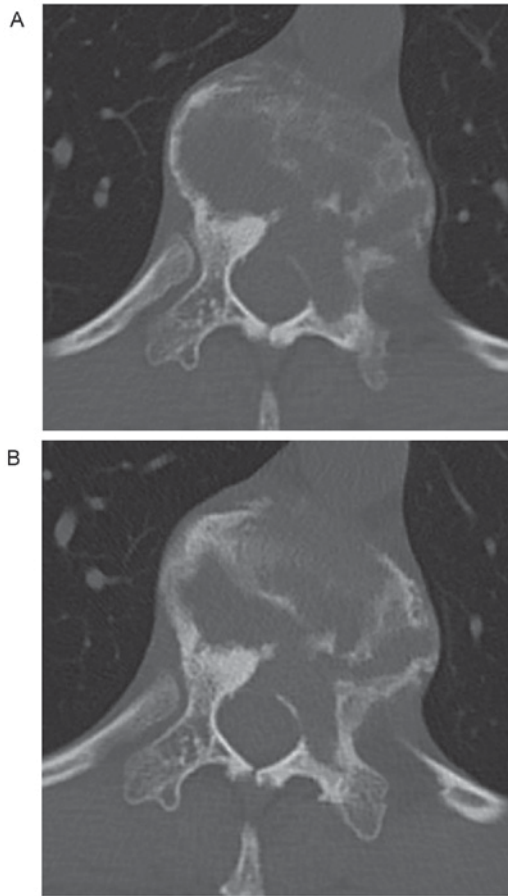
Computed tomography images captured during denosumab treatment. (A) At 3 months after starting denosumab therapy. (B) At 7 months after starting denosumab therapy. Consolidation of the vertebral cortex became increasingly visible as the border of the vertebral body and the soft tissue, including the spinal canal, were more easily distinguished compared with pretreatment images (Fig. 2A).
